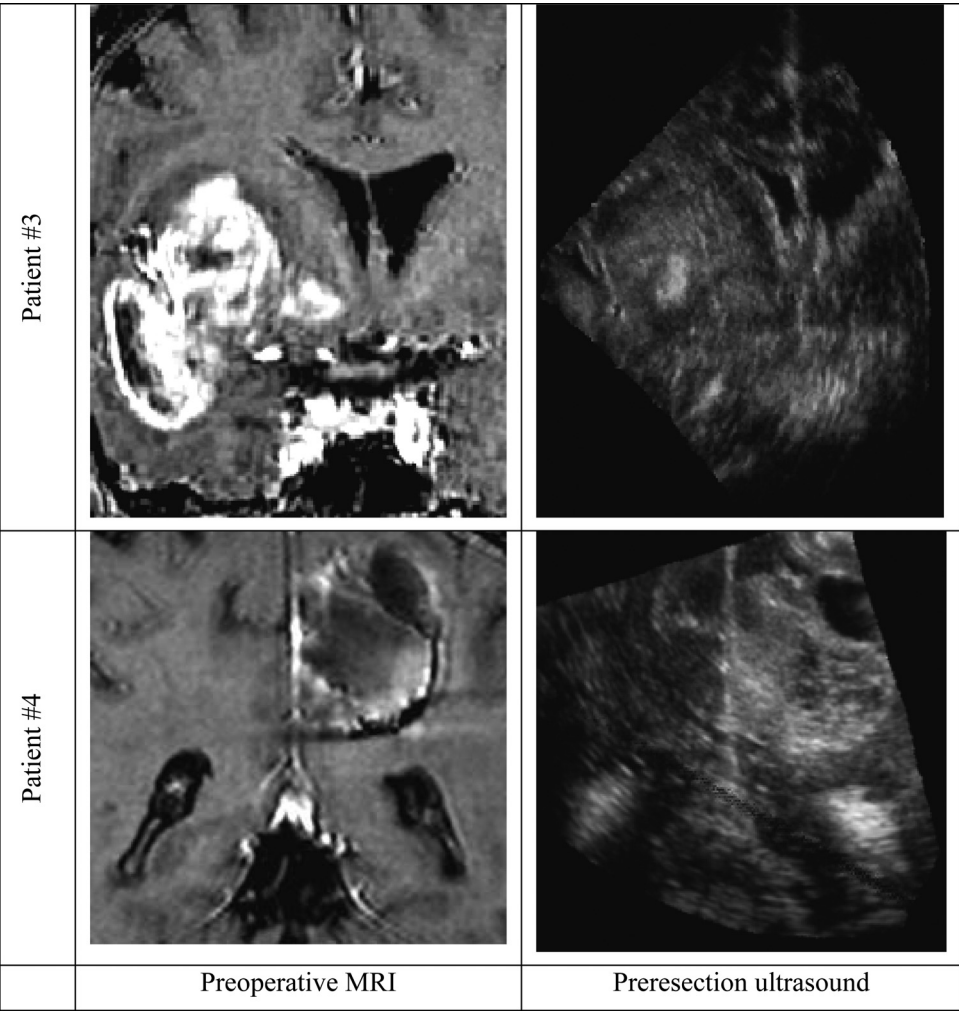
Left: reslice of preoperative MR images. Right: corresponding reslice of the preresection ultrasounds for patient #3 (upper row) and patient #4 (lower row).
